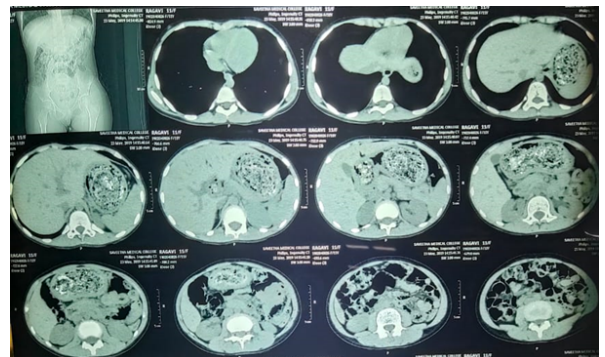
CT scan showing the stomach and duodenum filled with non-homogenous mottled gas patterned lesion
